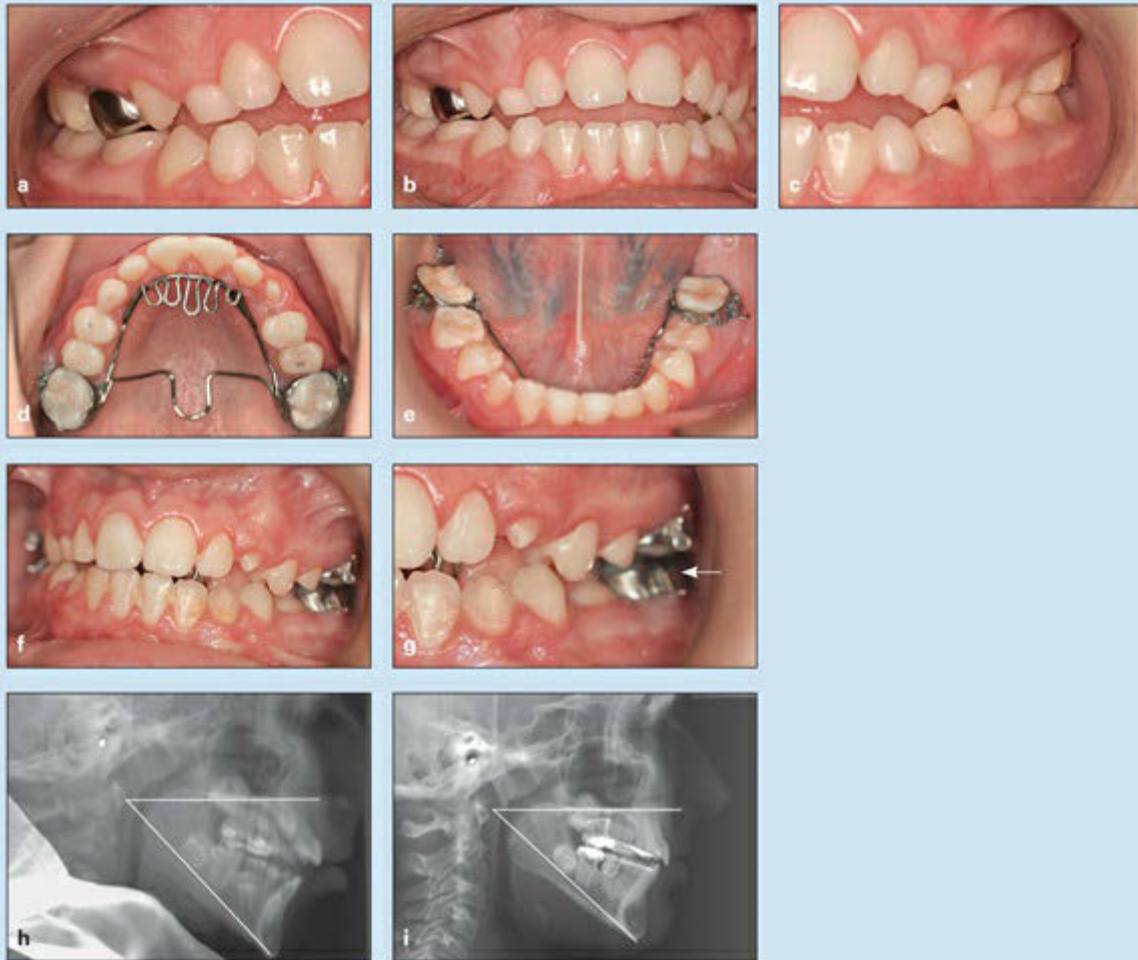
Management of Class I malocclusion and type III anterior open bite and tongue thrust in an 11-year-old girl. She has a vertical growth pattern and no history of finger sucking. (a to c) Pretreatment occlusion. (d) Combined TC-TPA for maxillary molar intrusion and tongue control. (e) Lower holding arch to control mandibular molar eruption. (f and g) Posttreatment occlusion with only 8 months of interceptive treatment. (arrow) Molar separation achieved by intrusion. (h) Pretreatment cephalometric radiograph. (i) Posttreatment cephalometric radiograph.
